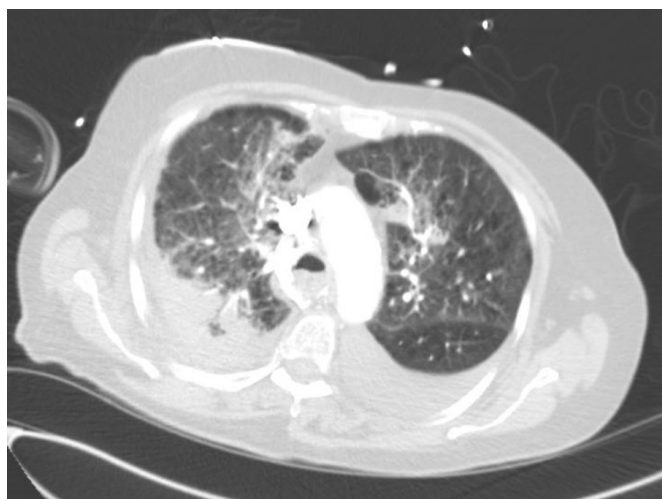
CT of the chest demonstrating bilateral ground-glass opacification and pleural effusions.
